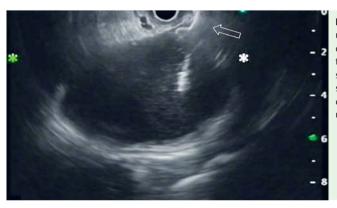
Endoscopic ultrasound (EUS) view of the distal flange of the lumen-apposing self-expanding metal stent (arrow) that was deployed completely under EUS guidance.
